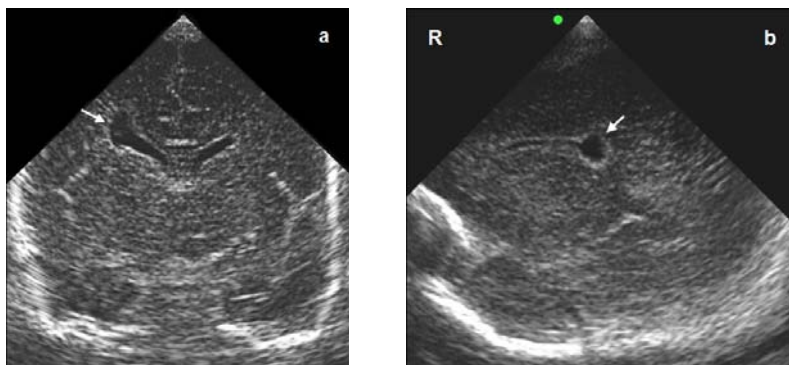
Coronal (a) and parasagittal (b) cUS of preterm infant (gestational age 27.0 weeks), scanned around term equivalent age (postmenstrual age 44.7 weeks), showing a porencephalic cyst in parietal white matter (arrows) (MRI-cUS white matter score: severely abnormal).
